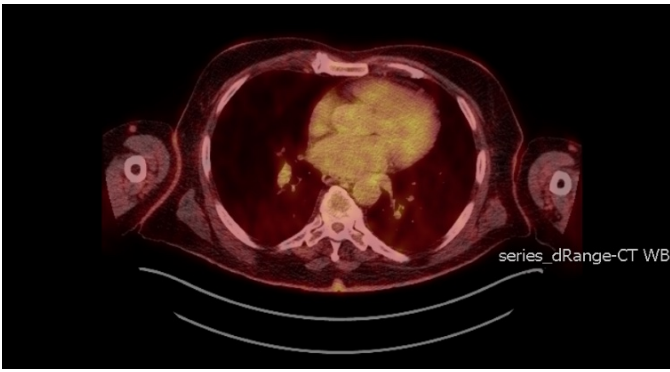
Right middle lobe hypermetabolic lung nodules with focal intense FDG uptake on PET-CT completed in January 2021.
